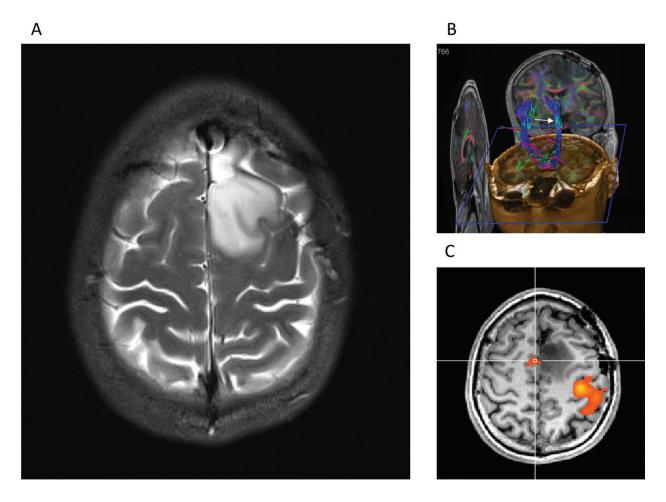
Preoperative images from a patient harboring a recurrent left frontal low-grade astrocytoma. Preoperative work up included T2-weighted magnetic resonance imaging (MRI) (A) showing the close relationship of the posterior tumor margin to the precentral gyrus, as well as MRI tractography and (B) showing the left-sided corticospinal tract displaced posteriorly (white arrow) by the tumor and a functional MRI of a right-sided finger-tapping paradigm showing activation in the area of the precentral gyrus' hand knob.
